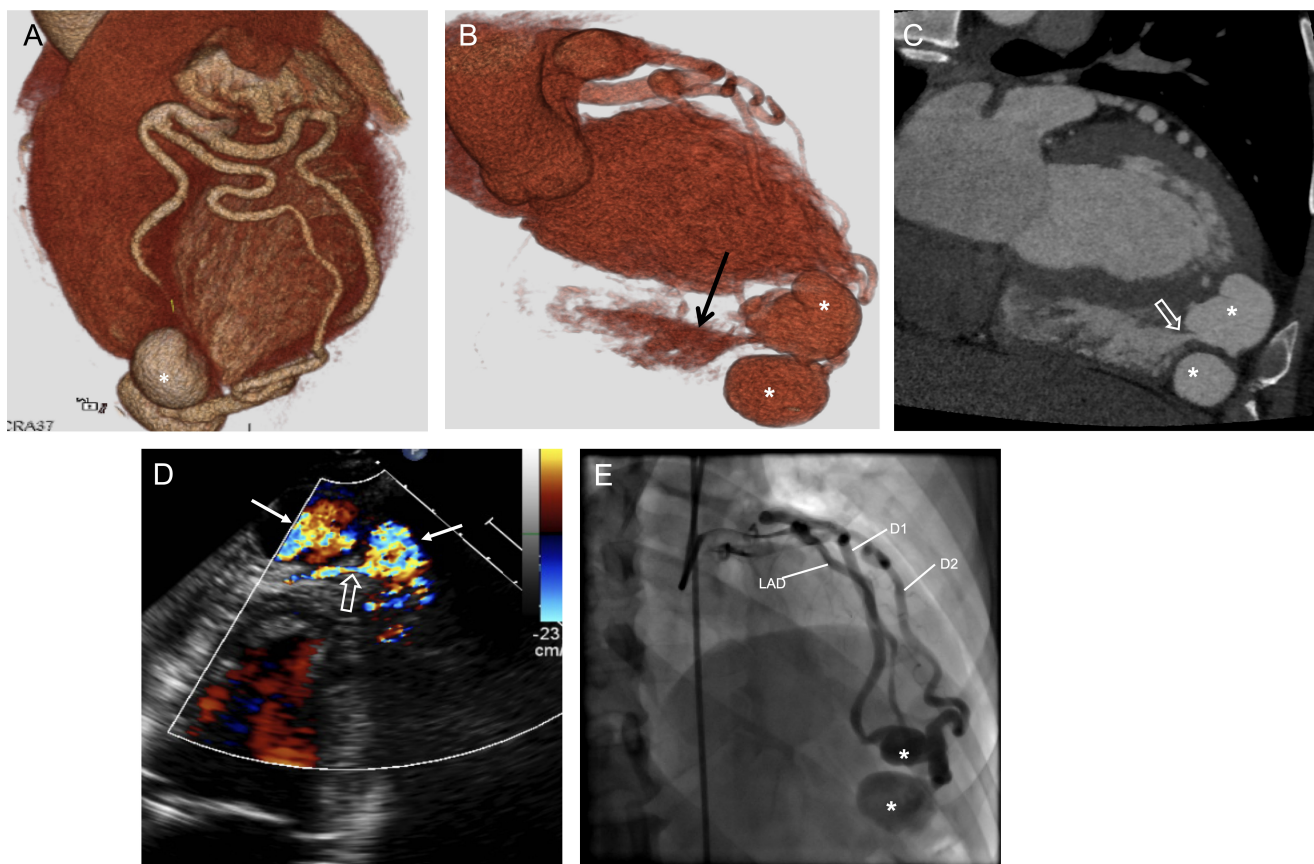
A 63-year-old man with chest pain. (A) and (B) Volume rendered CCTA images demonstrate bilobed aneurysm (*) supplied by the diagonal artery branches of the LAD and the communication between the aneurysmal segment and the right ventricular apex (arrow). (C) Coronal MIP image better demonstrates the communication between the aneurysmal segment and the right ventricular apex (open arrow). (D) Color Doppler echocardiography shows color mixing due to turbulent flow secondary to fistulous connection. (E) Conventional angiography shows ectatic feeding arteries and bilobed aneurysm (*).
